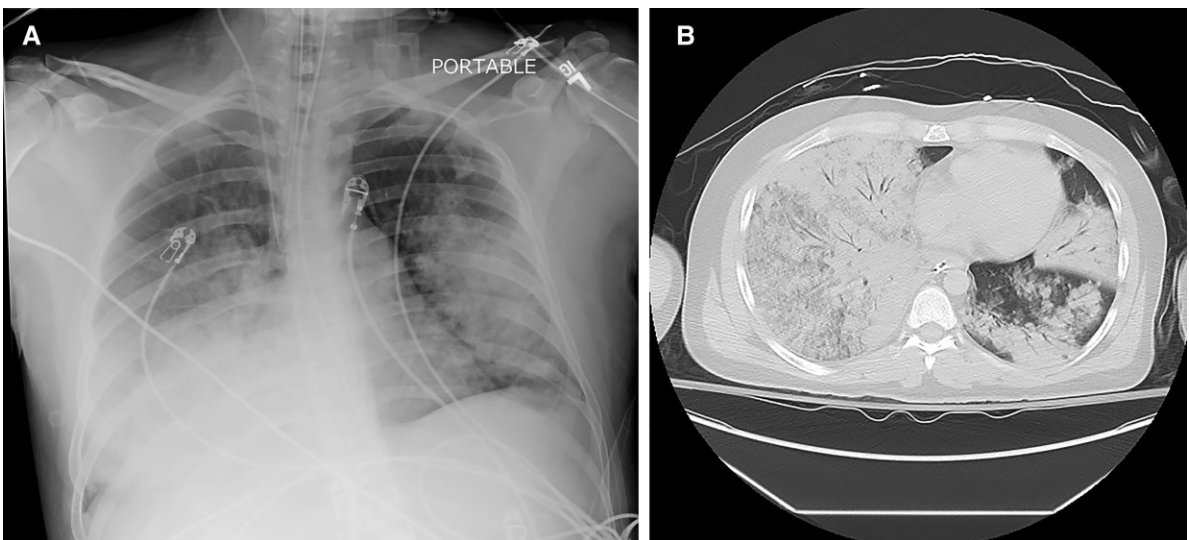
A, Chest radiograph for case patient 2 showing bilateral alveolar infiltrates consistent with pneumonia. B, Computed tomography abdomen lung window in case patient 2 showing diffuse bilateral consolidation.
